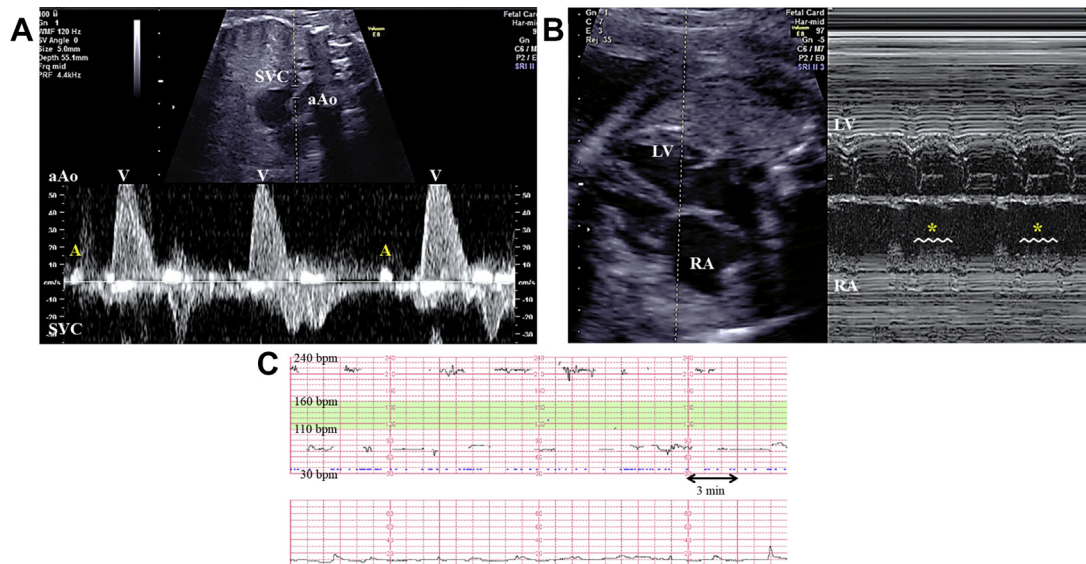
Paroxysmal atrial fibrillation (PAF). PAF was confirmed by M-mode recording at 30 weeks of gestation. A: Doppler recording of superior vena cava (SVC)–ascending aorta (aAo) flow showed irregular bradycardia with a ventricular rate of 70–90 beats per minute (bpm). The A wave frequently disappeared. B: M-mode recording using a 4-chamber view also showed irregular bradycardia. Atrioventricular dissociation was present, with a ventricular rate of 70–90 bpm and an atrial rate of 40–50 bpm. After a clear atrial contraction, the unique quivering of the atrial wall (*) was observed, suggesting PAF. C: Fetal baseline heart rate intermittently fluctuated between 70 and 215 bpm on cardiocography. LV = left ventricle; RA = right atrium.
